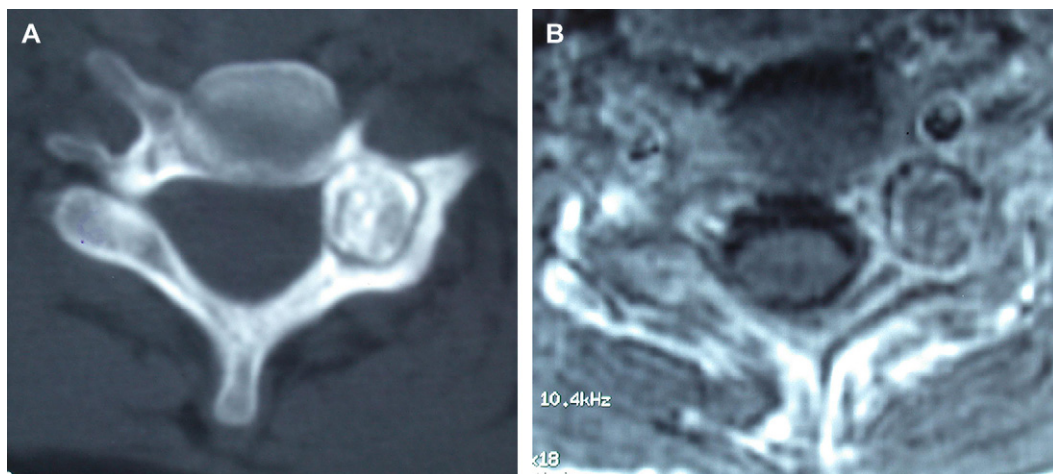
Axial images of a cervical osteoblastoma showing central nidus and surrounding sclerotic rim on (A) CT and (B) MRI.
